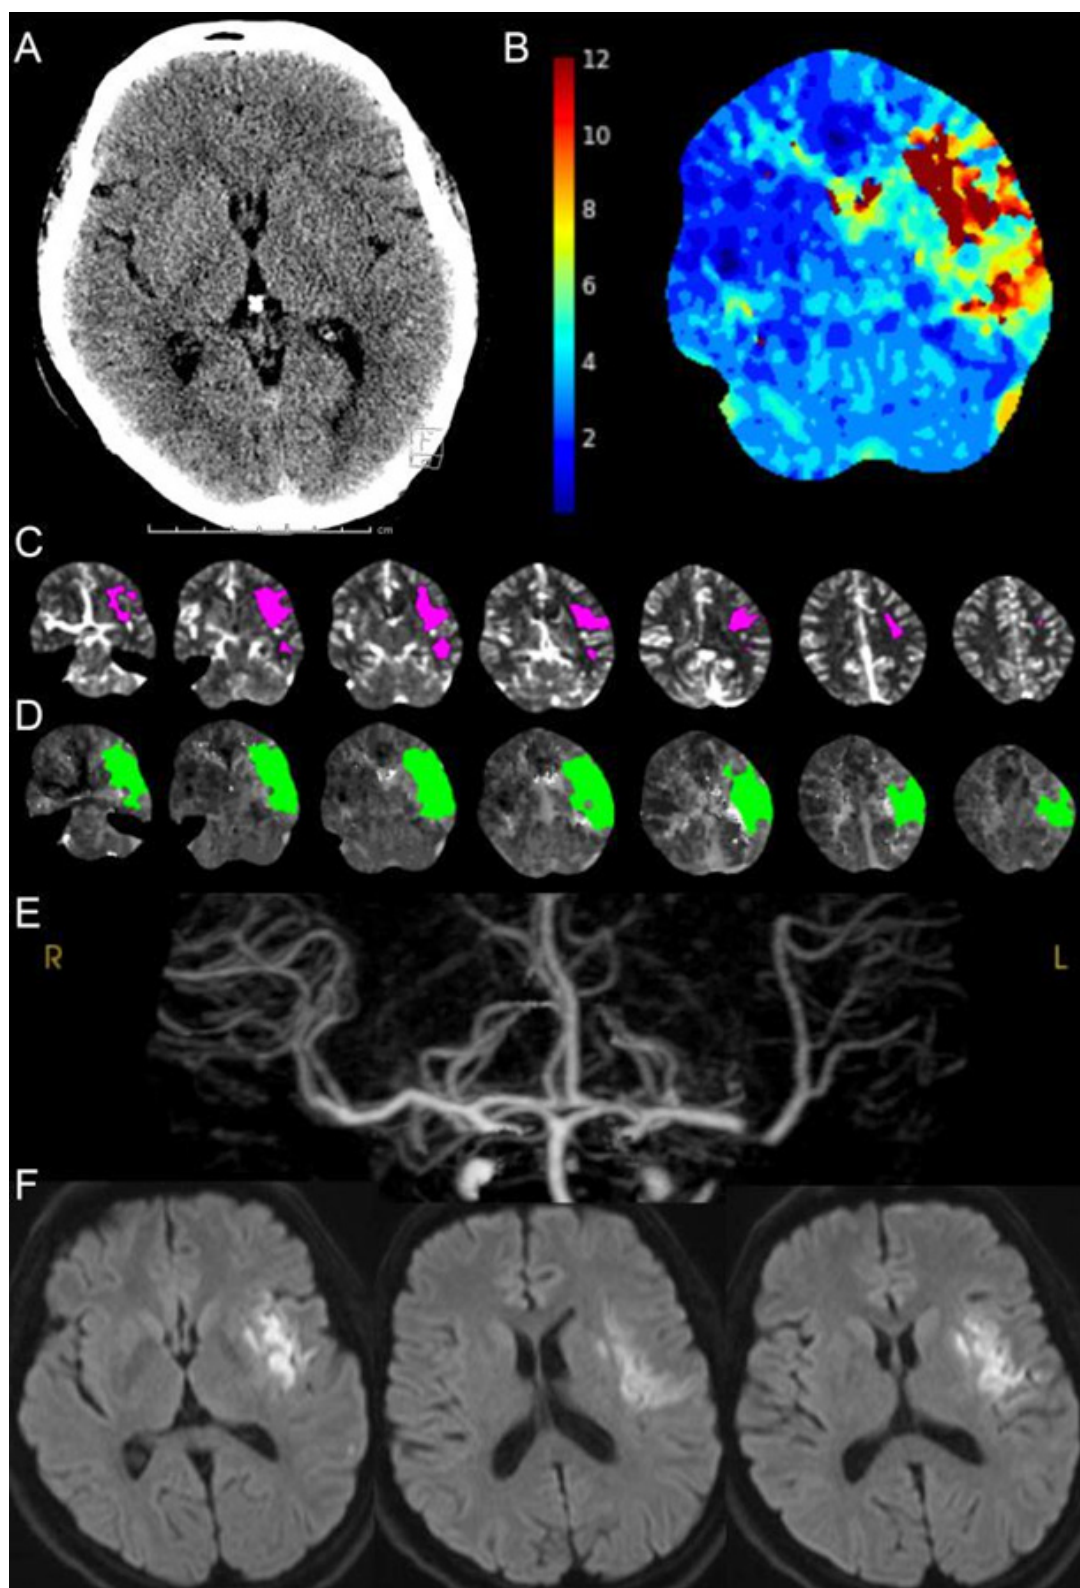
A patient with wake-up onset stroke. Non-contrast CT excluded hemorrhage and indicated subtle loss of grey-white differentiation in the left insular region (A); CT perfusion time to maximum (Tmax) map showing delayed flow via collaterals in the left middle cerebral artery territory confirmed the diagnosis of ischemic stroke (B); Automated segmentation of CT perfusion cerebral blood flow < 30% of normal brain (36 mL magenta region estimated as irreversibly injured ischemic core) (C) and Tmax > 6-s delay (124 mL green region estimated tissue at risk) from RAPID software (D); CT angiography demonstrating distal M1 middle cerebral artery occlusion (E) 24-h diffusion MRI after successful endovascular thrombectomy showing no interval growth in ischemic core (F)
